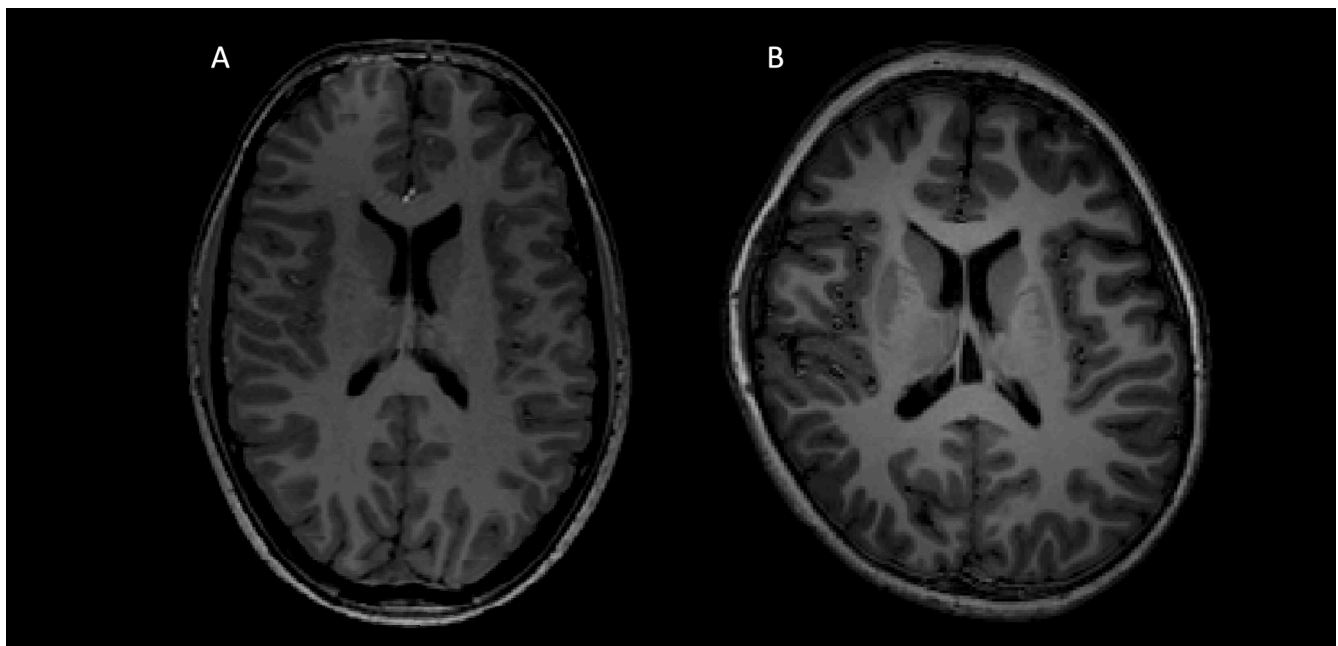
Representative T1-weighted images. An age-matched healthy control (A) and a patient with DMD (B).
